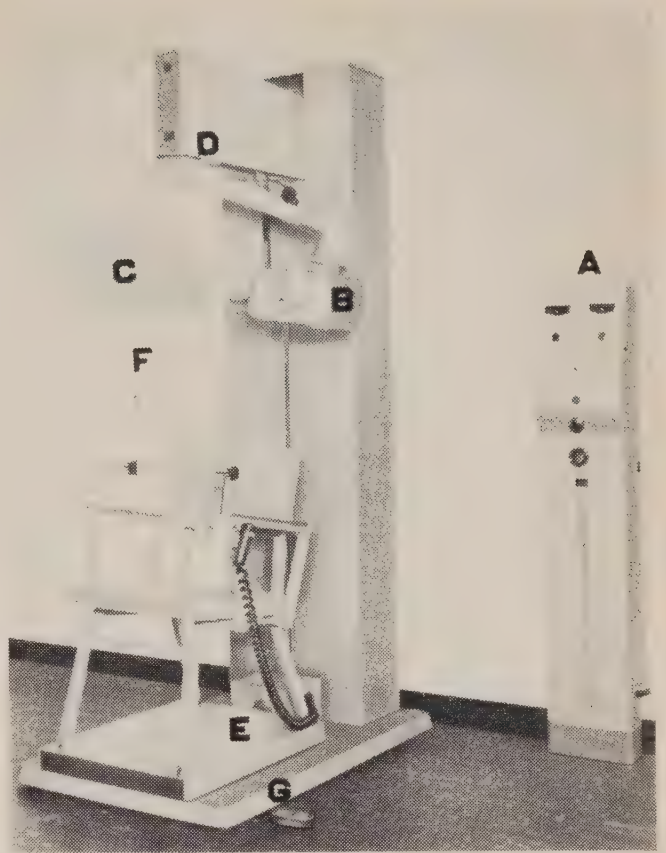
Panorex tomographic instrument modeled after prototype developed by U.S. Bureau of Standards and U.S. Air Force. A, Controls and transformer. B x-ray tube. C, Film cassette holder, with narrow exposure slit. D, Cam and cable assembly for rotating x-ray tube and film holder around stationary patient. E, Chair and base for patient. Base shifts three inches to change rotational axis when film holder and x-ray tube reach midsagittal plane in their rotational cycle. Hand control hangs on chair when not in use. F, Chin rest. G, Foot control to raise and lower exposure assembly B, C, D to fit patient in chair.
